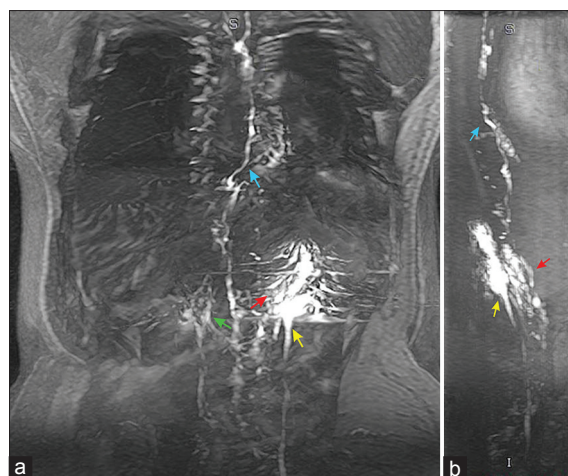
Coronal (a) and sagittal (b). Maximum intensity projection images of magnetic resonance imaging-Gadolinium retrograde pyelography of the left kidney with visualization of multiple transverse opacified lymphatic channels in the left perinephric region (red arrow) with few lymphatics refluxing across the midline to the contralateral right perinephric lymphatics (green arrow). These lymphatics are seen draining into the thoracic duct (blue arrow) right up to the thoracic inlet on the left side. Left renal pelvis and left ureter is also well-visualized (yellow arrow)
